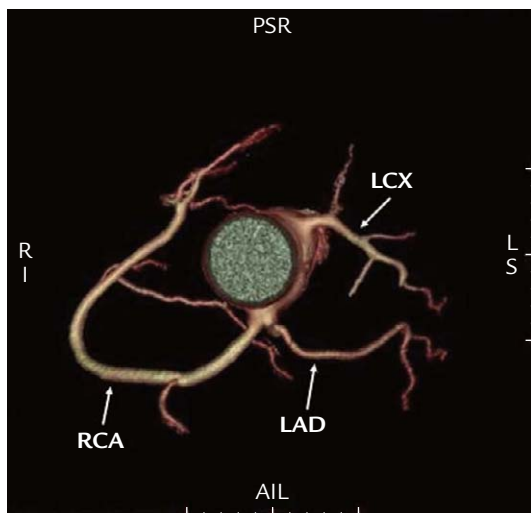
Type III coronary artery anatomic variant as shown on 64-multidetector-row computed tomography. The right coronary artery (RCA) and left anterior descending artery (LAD) originate from sinus 2. The left circumflex artery (LCX) originates from sinus 1.
